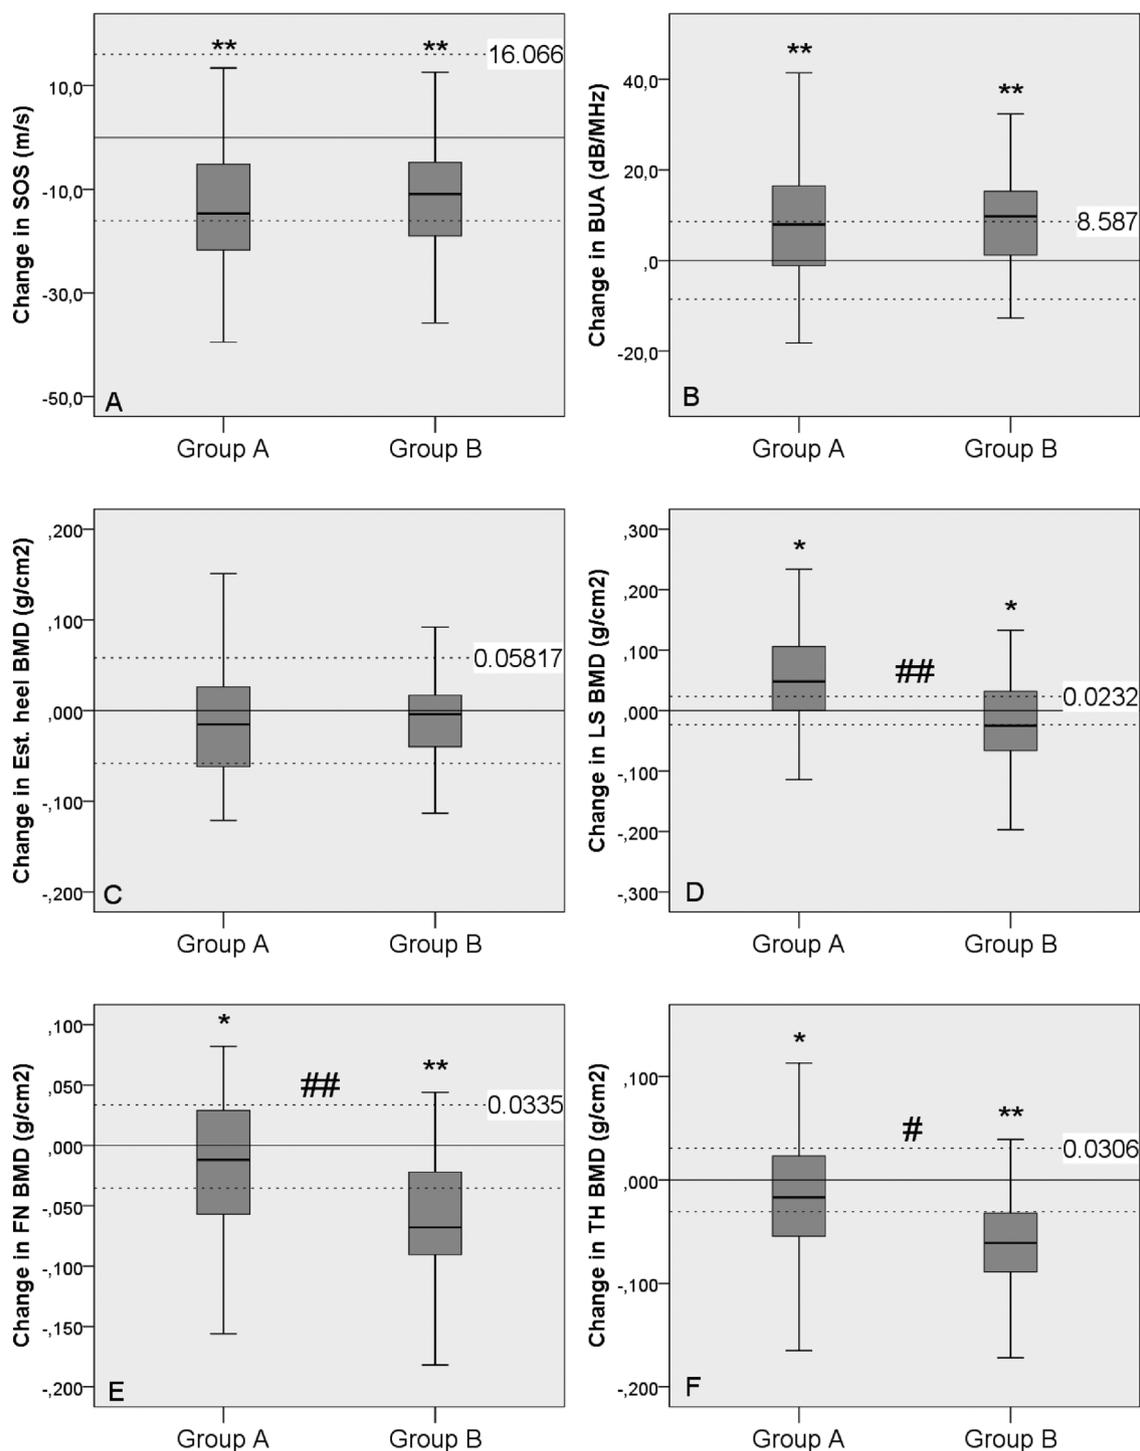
Absolute changes of bone data measured in patients treated (group A) and patients not treated with bisphosphonates (group B) for A.) Speed of sound, B.) Broadband ultrasound attenuation, C.) Estimated heel BMD, D.) Lumbar spine BMD, E.) Femoral neck BMD and F.) Total hip BMD. Positive and negative Significant Changes are shown as interrupted lines. *p < .05, p < .001 versus baseline, #p < .05, ##p < .001 between groups. SOS = speed of sound, BUA = broadband ultrasound attenuation, Est. heel BMD = estimated heel bone mineral density, LS = lumbar spine, FN = femoral neck, TH = total hip
